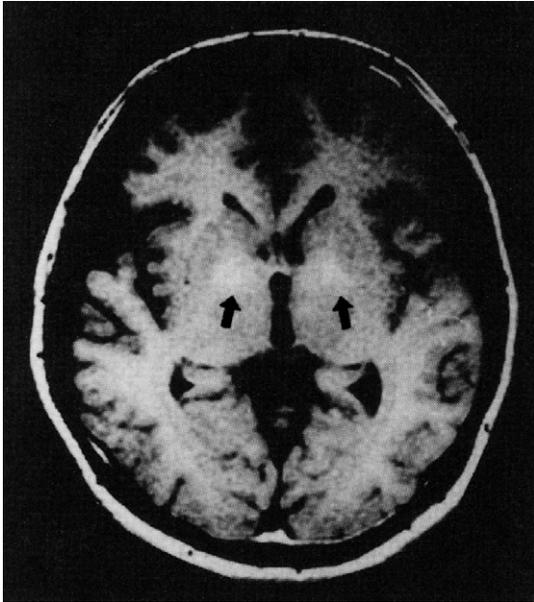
T1-weighted MRI. High-signal regions are seen in the globus pallidus bilaterally (arrows) from Murata et al. [20].
